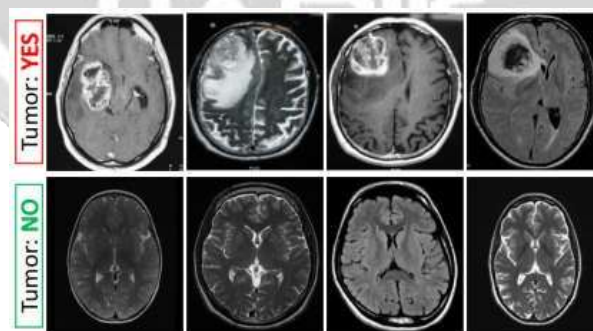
Brain MRI images dataset sample
